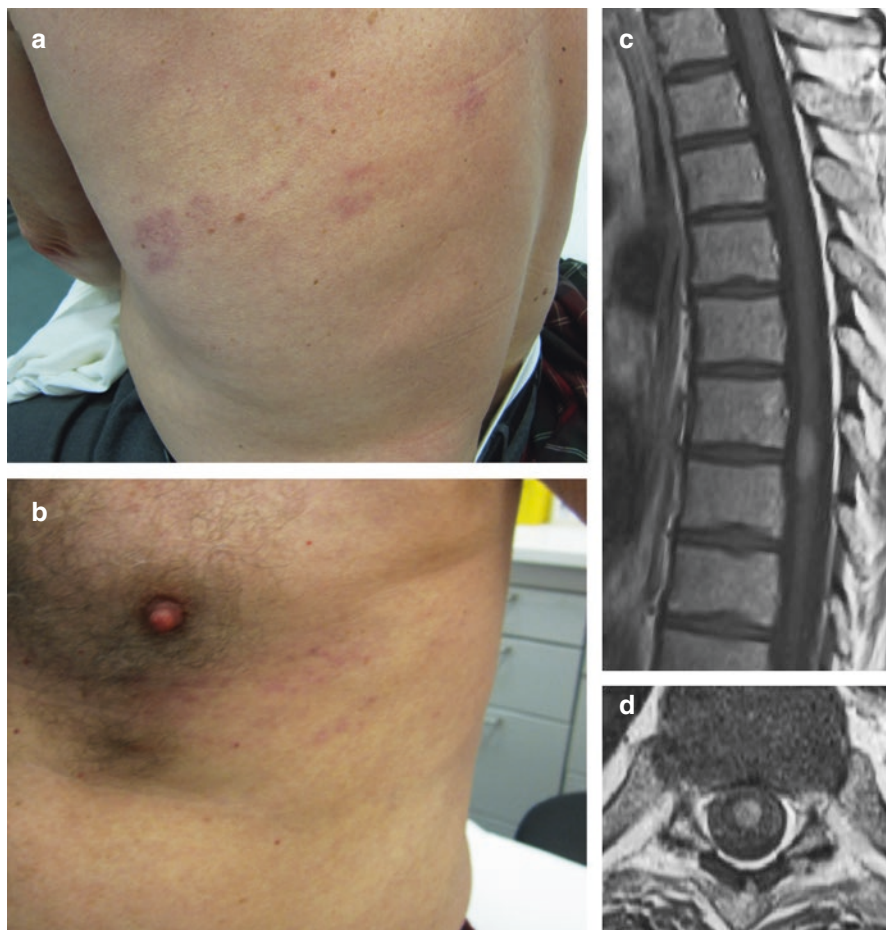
VZV myelitis. (a, b) Herpes zoster skin lesion in a 70-year-old man presenting with paraparesis, urinary incontinence and sensory level Th7. T1-weighted (c) sagittal and (d) axial images of the thoracic spinal cord showing a well-demarcated focal intramedullary lesion with gadolinium enhancement (Images courtesy of Prof. Erich Schmutzhard, Neurology, and Prof. Elke Gizewski, Neuroradiology, Innsbruck Medical University)
